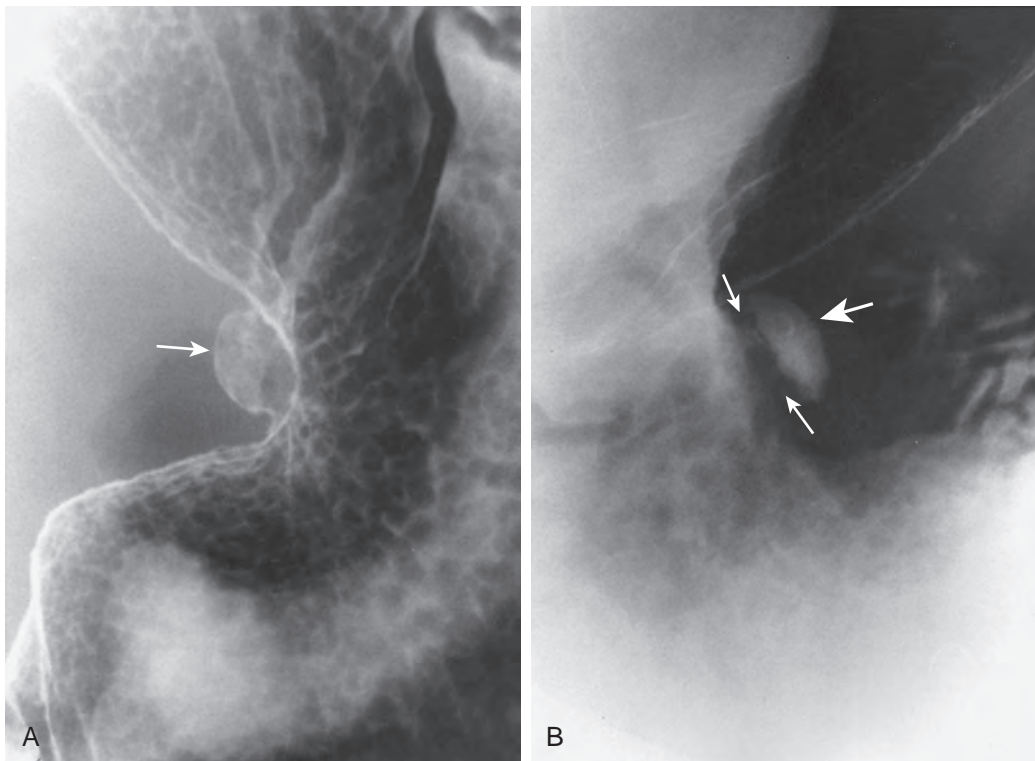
Lesser curvature ulcers. A. A smooth, round ulcer (arrow) is seen projecting beyond the lesser curvature. The radiating folds and enlarged areas gastricae in the adjacent mucosa are caused by surrounding edema and inflammation. B. In another patient, a lesser curvature ulcer (large arrow) is demonstrated on a prone compression view. Note the radiolucent band of edema or ulcer collar (small arrows) adjacent to the ulcer. Both these cases demonstrate classic features of benign gastric ulcers. (A from Levine MS, Creteur V, Kressel HY, et al: *Benign gastric ulcers: Diagnosis and follow-up with double contrast radiography*. *Radiology* 164:9–13, 1987.)
